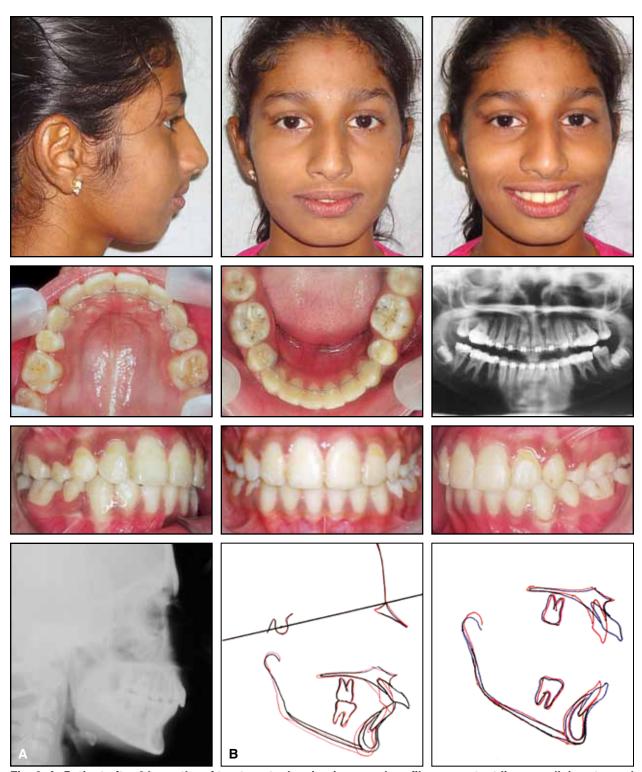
A. Patient after 24 months of treatment, showing improved profile, competent lips, parallel roots, and no sign of root resorption. (Panoramic radiograph taken at end of space-closure phase.) B. Superimposition of pre- and post-treatment cephalometric tracings, indicating anchorage preservation and significant incisor retraction.
